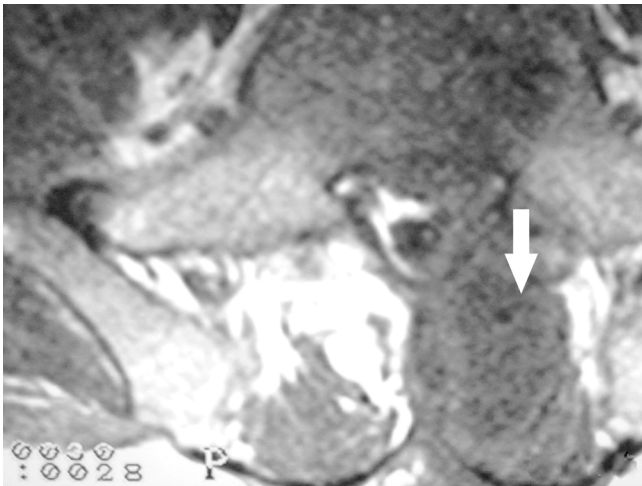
Axial T1-weighted magnetic resonance image shows an ellipsoid hyperintense lesion at the left paravertebral region.
